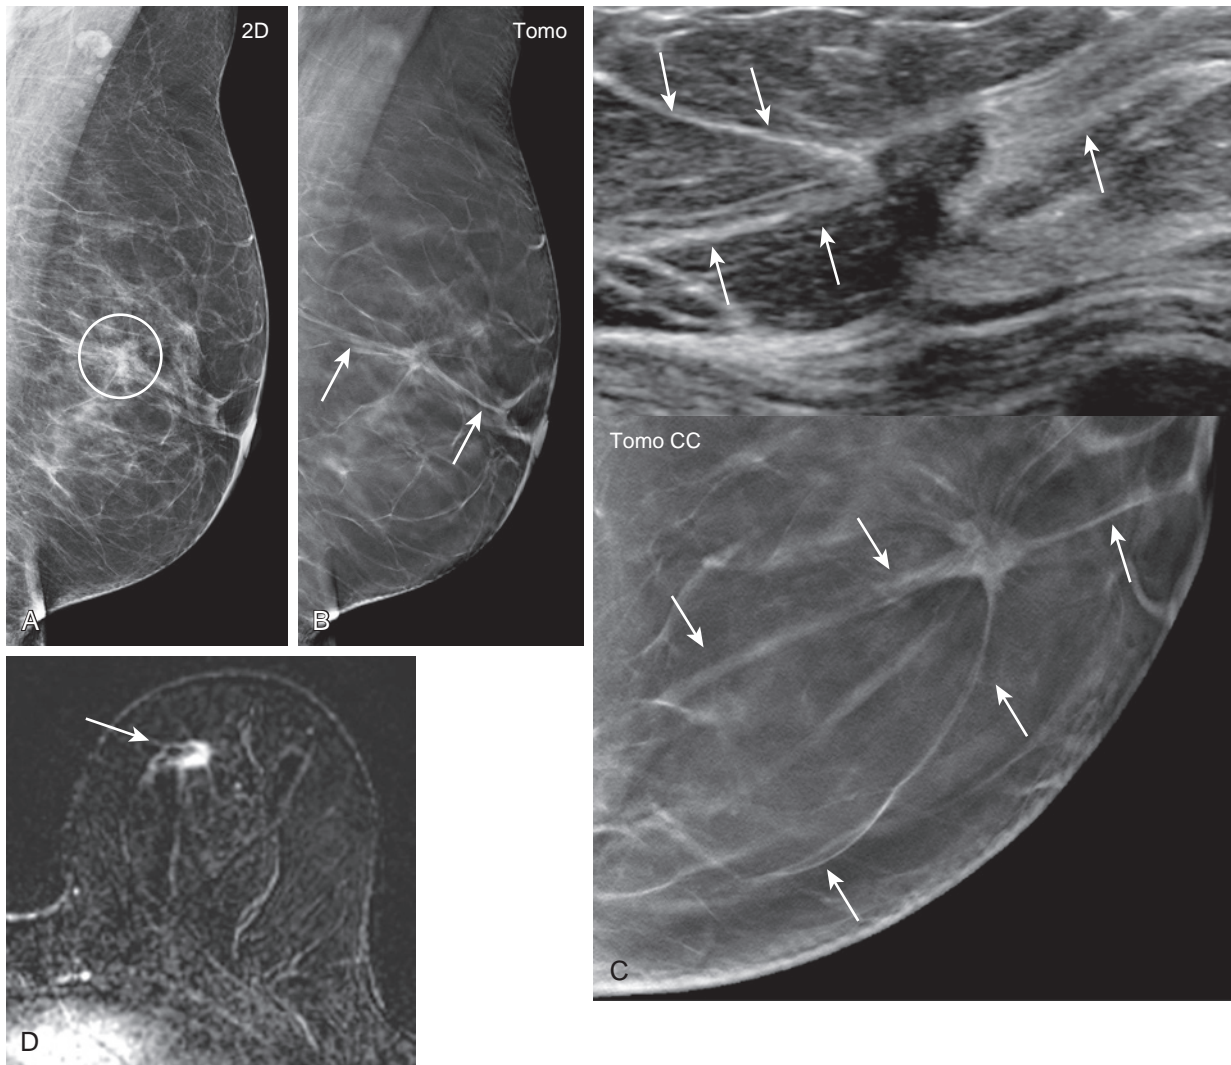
Invasive ductal cancer with very prominent spicules on tomosynthesis (A) A 54-year-old woman with focal irregular asymmetry (*circle*) in the left superior medial breast on screening mammography, initially best seen on two-dimensional MLO view. (B) Tomosynthesis reveals a mass with extensive spicules (*arrows*) extending across the entire anteroposterior extent of the breast. (C) Targeted ultrasound demonstrates a 0.8-cm mass with straightening of the nearby Cooper ligaments (*arrows*), mirroring the mammographic image. Ultrasound-guided core needle biopsy showed a grade 2 IDC. (D) Magnetic resonance imaging was performed to assess the tumor size preoperatively. A post-contrast, fat suppressed, and subtracted T1-weighted image shows a corresponding enhancing mass (*arrow*) without the associated long spicules seen mammographically. Surgical pathology showed grade 2 IDC, ER/PR+, Her2-, 0/3 SLN. Final pathologic tumor size was 1.2 cm and best correlated with MRI.
